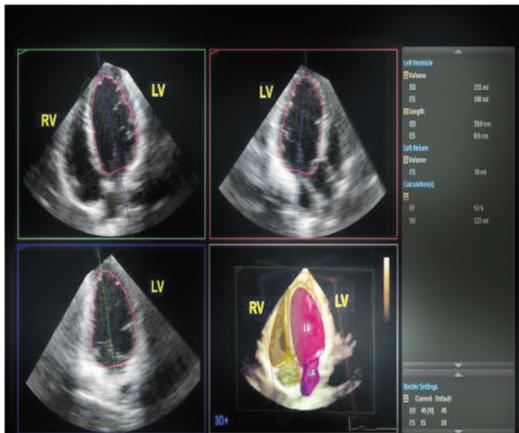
An example of transthoracic three-dimensional Heart-Model dataset with surface reconstruction display of all four cardiac chambers, left atrium volume, left ventricle volumes and ejection fraction. LV=left ventricle; RV=right ventricle.
